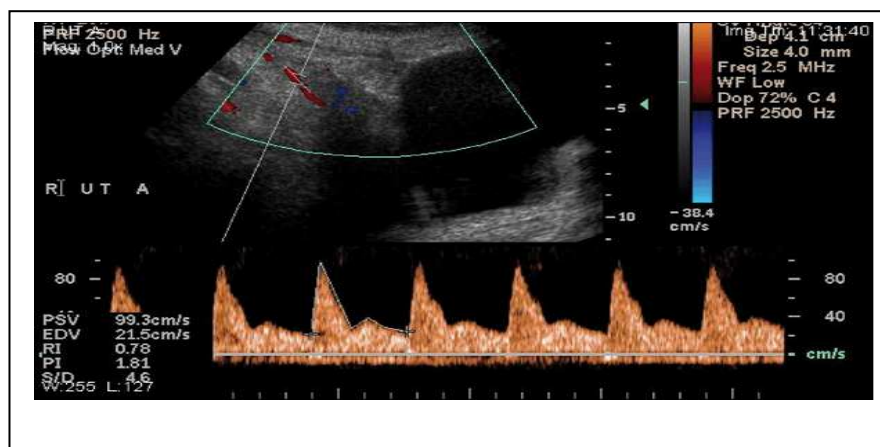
Uterine artery Doppler study with reporting.(right side)
